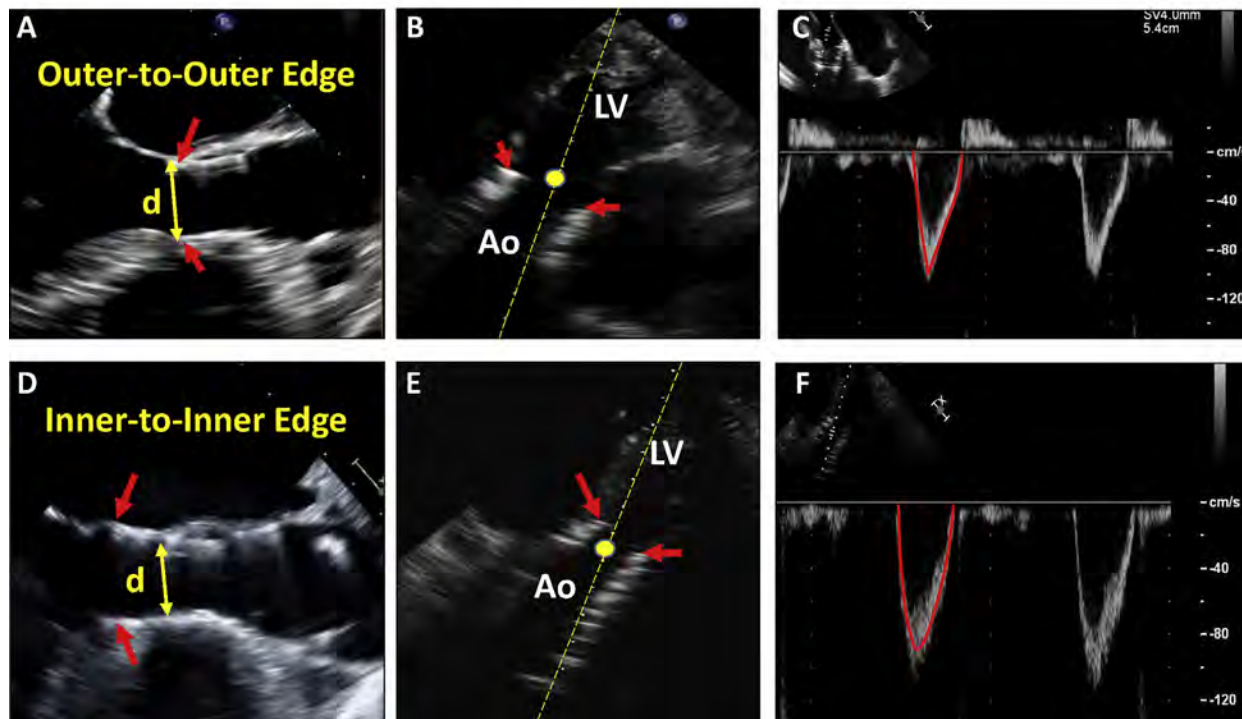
Calculation of stroke volume in the LVOT in transcatheter aortic valves. The default approach is to measure the LVOT diameter using the outer edge-to-outer edge diameter at the lower (ventricular) end of the valve stent (A, arrow). The pulsed-wave Doppler (PWD) sample volume is placed immediately proximal to the site of flow acceleration at the inlet to the stent (B). Stroke volume is then calculated as usual, assuming a circular LVOT geometry as: $0.785 \cdot d^2 \cdot \text{VTI}$. In instances where a self-expanding valve is placed low in the LV, particularly if the lower end of the stent is not in close proximity to the anterior mitral leaflet and interventricular septum, an alternative approach is to measure the inner edge-to-inner edge diameter of the valve stent immediately proximal to the cusps (D). The PWD sample volume should be placed just inside the stent but proximal to the site of flow acceleration at the cusps (E). Note that with transcatheter valves there is flow acceleration at the inlet to the stent and again at the cusps. Red arrows point to the lower end of the stent. Panels C and F show the respective PWD recordings in the LVOT.
